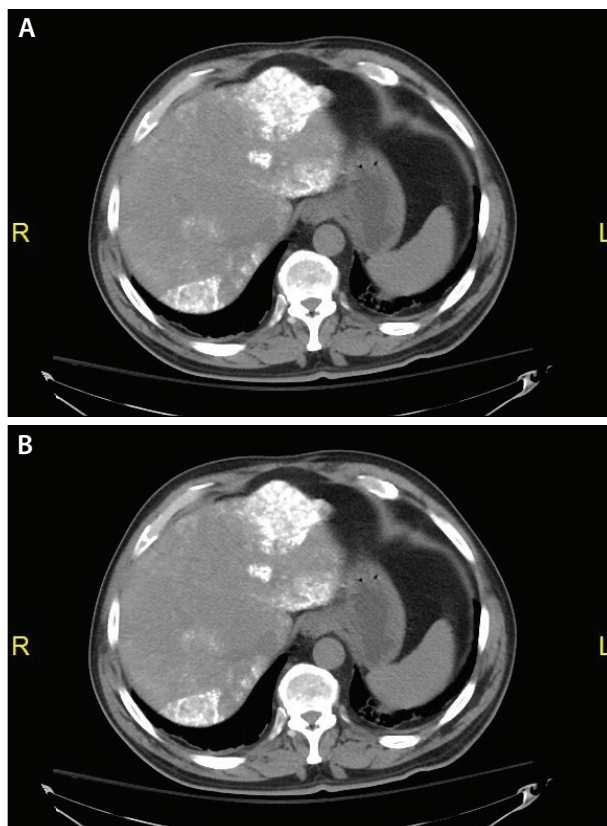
Postembolization CT scans.
